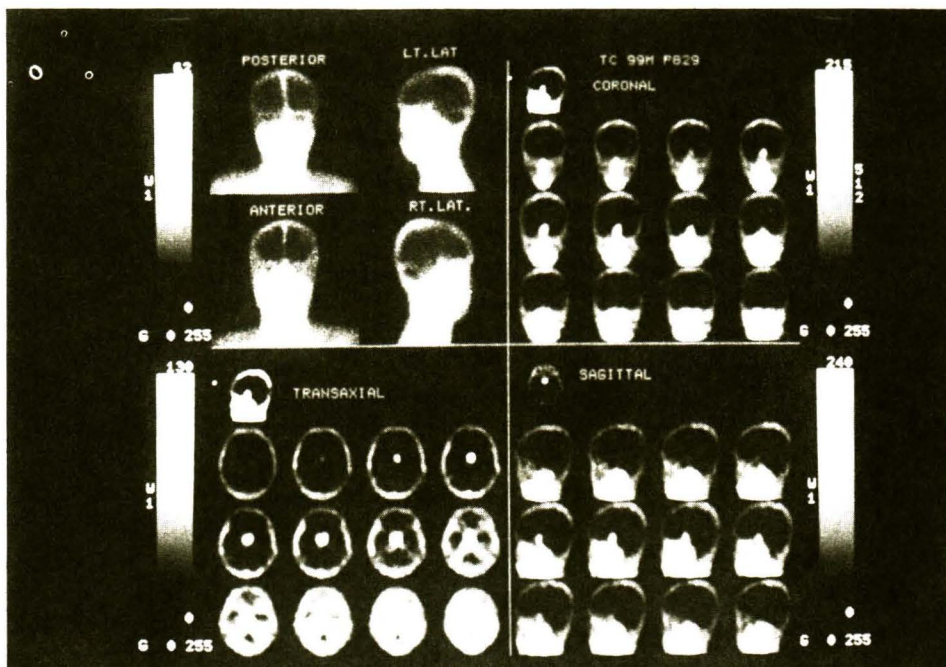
Planar and SPECT images at skull revealed positive somatostatin receptor imaging (^{99m}Tc P829) in a functionless pituitary adenoma.
